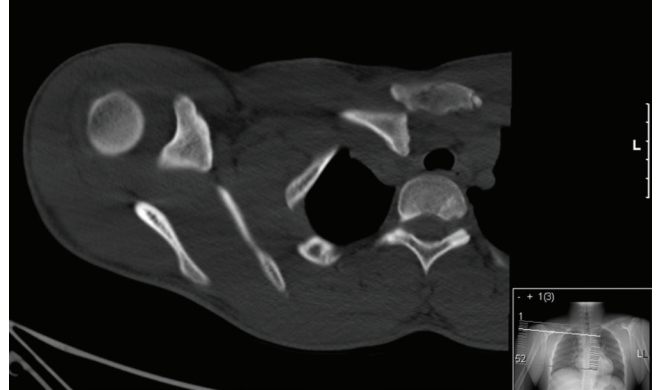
CT (axial view) showing incongruence of the right sternoclavicular joint, with posterior displacement of the clavicle.
